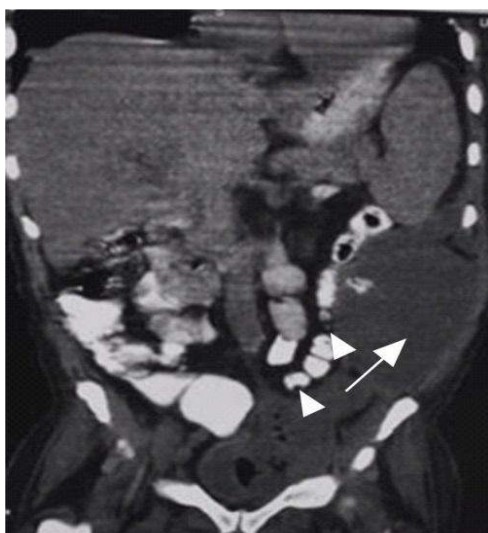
Coronal Abdominal CT showing diverticula (arrowheads) with large Intraabdominopelvic abscess (arrow)
